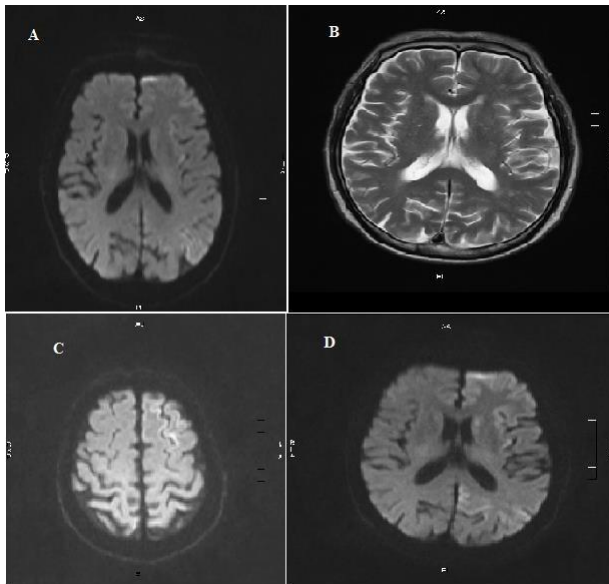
A. FLAIR B.T2WI, C and D. DWI sequences of MRI showing hyperintense signal in left occipital and frontoparietal cortex in DWI and FLAIR sequences.
